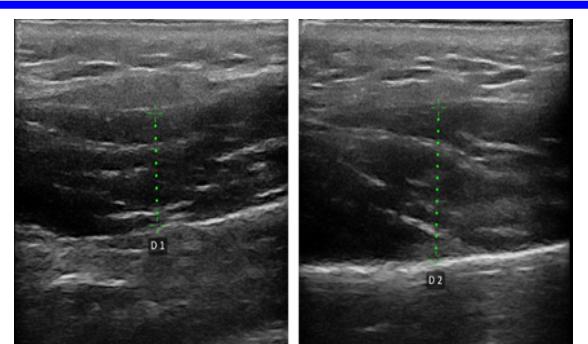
Ultrasonographic image showing the masseter muscle in both a resting position (A) and during contraction (B).
